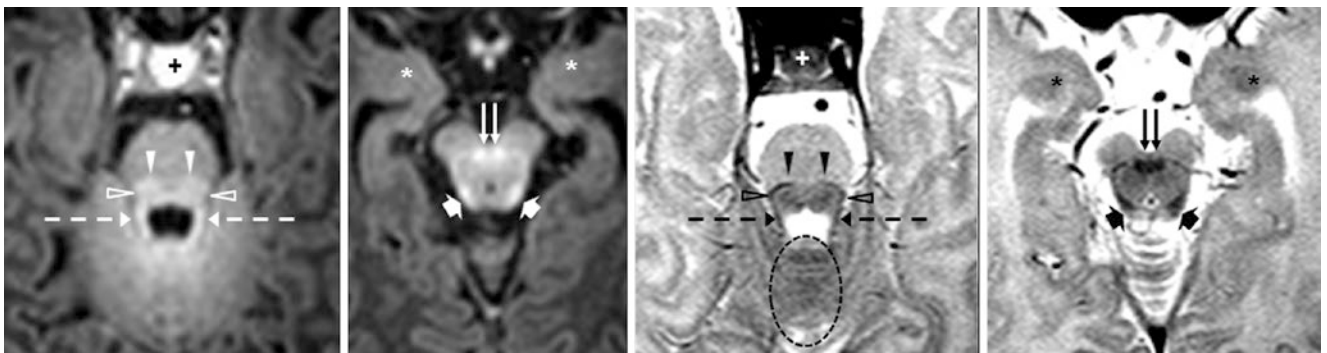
A 6-day-old term neonate had a normal 3T MRI with GE T1WIs (*left images*) and SE T2WIs (*right images*). The BIC/inferior colliculi (*wide arrows*), DSCP (*double arrows*), LL (*open arrowheads*), ML (*arrowheads*), and SCP (*dashed arrows*) all appear myelinated.
